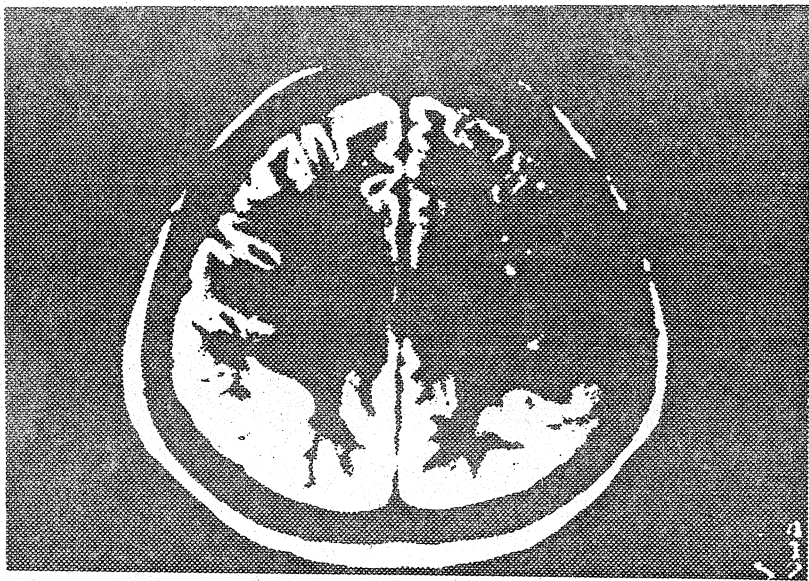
MRI shows areas of increased signal in the white matter of the periventricular region predominantly on the left side (arrows).
